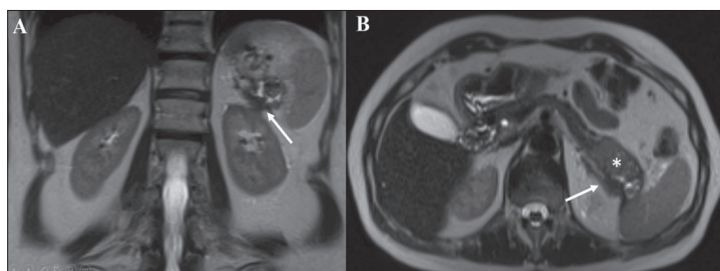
Coronal T2-weighted magnetic resonance image (A) shows propagation of the pancreatic tail tumor in perirenal fat plane with infiltration of the renal capsule (arrow); axial T2-weighted MR image in the same patient (B) shows infiltration of the left adrenal gland (arrow); the pancreatic tail tumor is shown on B (asterisk)
